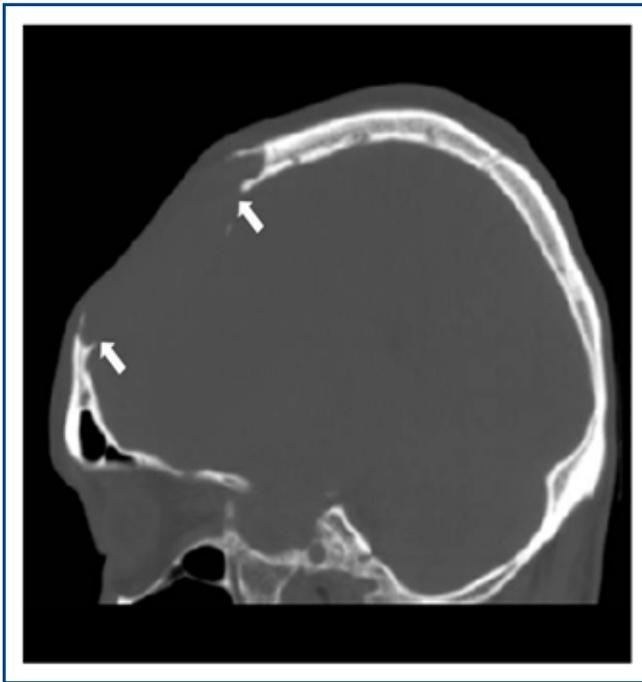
CT Sagittal multiplanar reformation shows a well demarcated osteolytic lesion (arrows).
